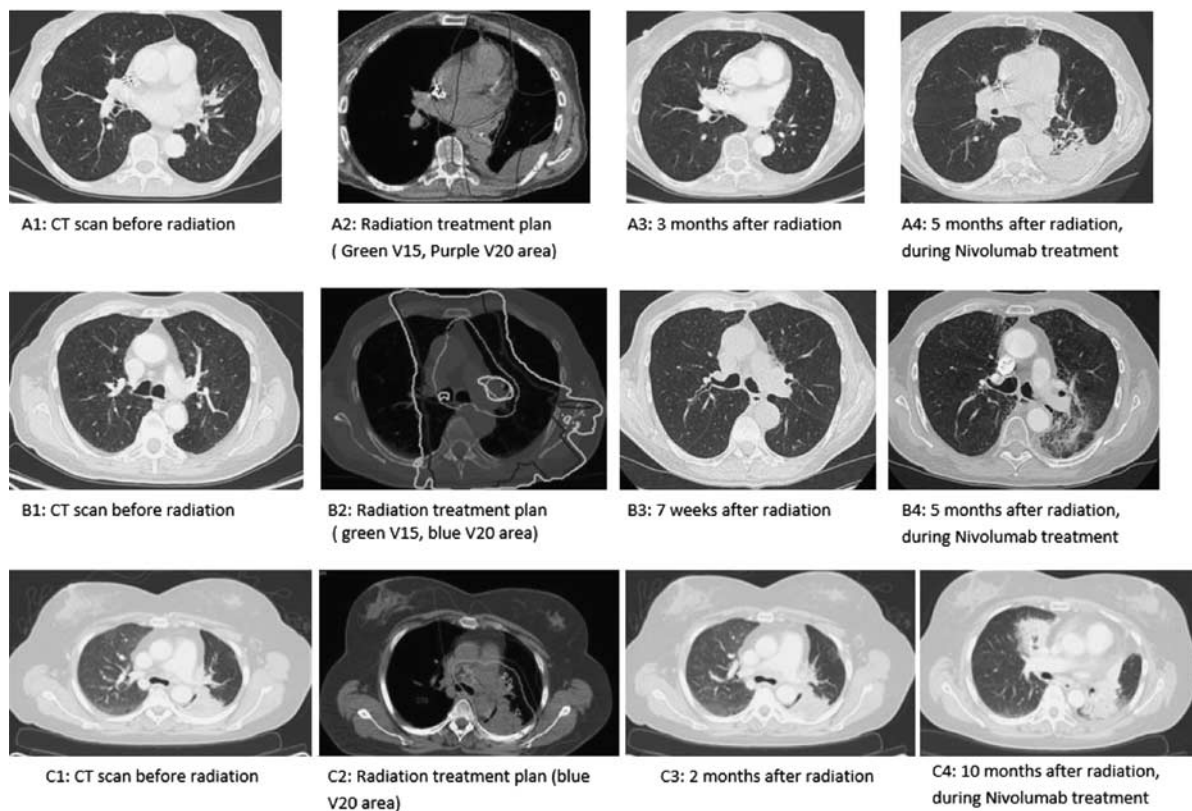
A–C, Diagnostic, radiotherapy and follow-up computed tomography (CT) imaging.
